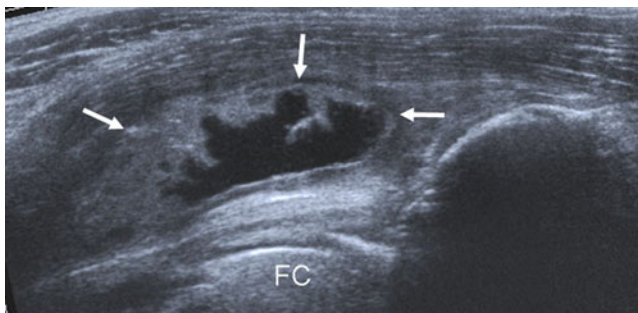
Ultrasound showing a thick-walled reactive mass anterior to the joint (*arrows*). FC = Femoral component
